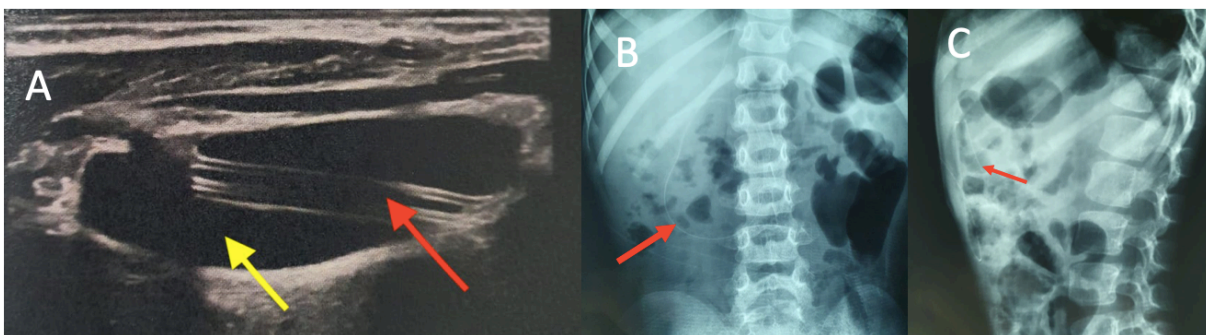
A- Abdominal ultrasound of the gallbladder, indicating the distal catheter (red arrow) and gallbladder lumen (yellow arrow). B - AP X-ray showing distal catheter (red arrow). C - Lateral view X-ray showing distal catheter (red arrow)
